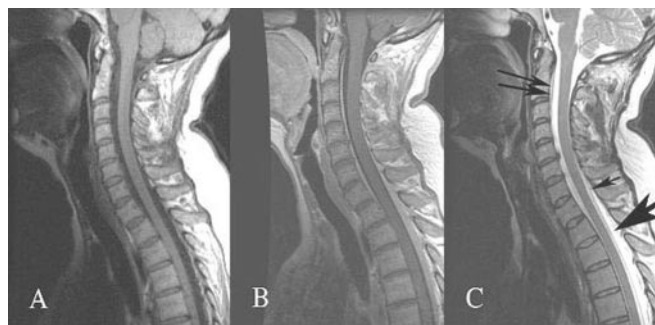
(A) Sagittal cervical and upper thoracic spinal T1 image showing normal spinal cord and epidural space. (B) In contrast to normal non-enhanced T1 imaging, simultaneous sagittal postcontrast T1-weighted imaging of the same region demonstrates abnormal increased signal in the epidural space suggesting epidural venous engorgement leading to flow stasis. (C) Sagittal T2 image also highlights epidural space prominence (large arrow), dural edge (small arrow) with thin line of subarachnoid CSF visible, and suggestion of an extra-axial fluid collection (double arrows).
